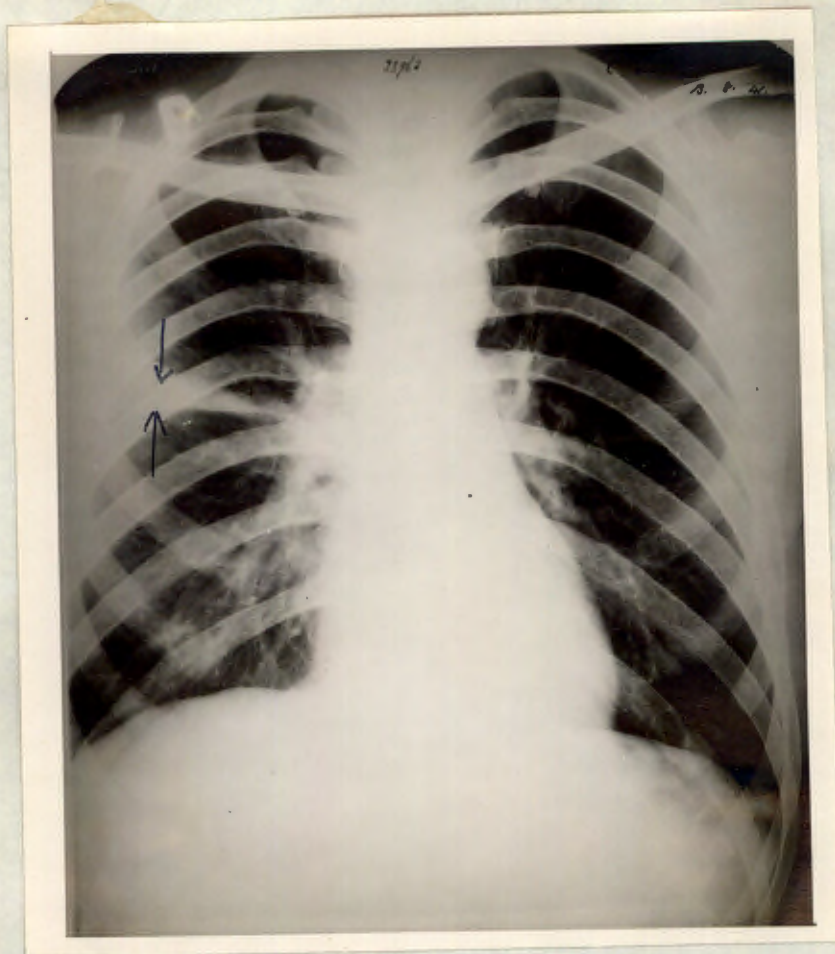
Postero-anterior radiograph showing marked thickening of the lesser interlobar fissure due to fluid.
